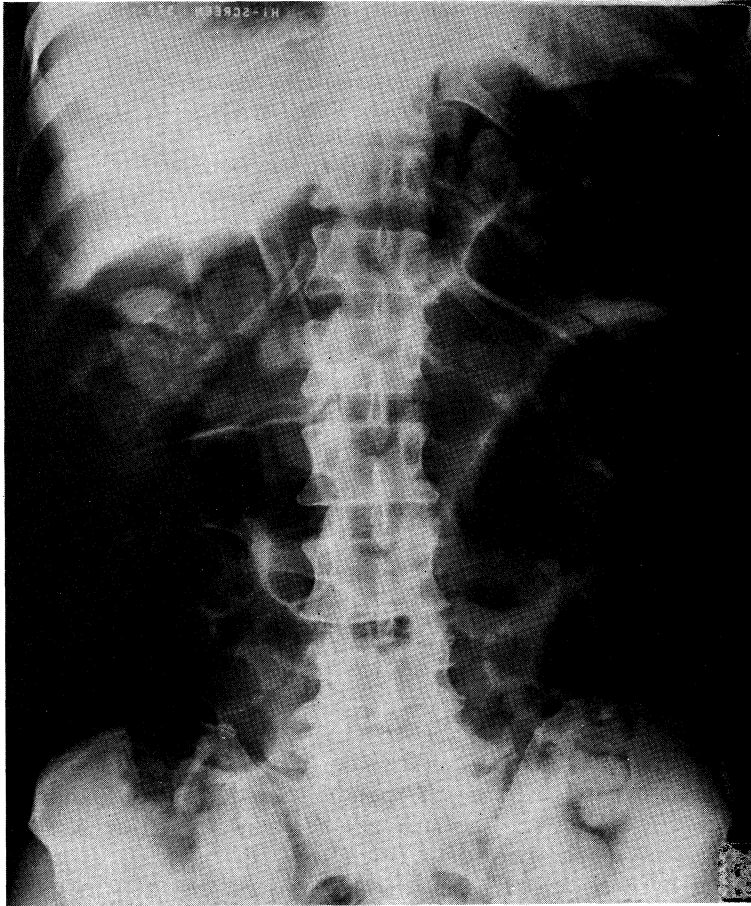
Plain antero-posterior X-ray films of the abdomen showing paralytic ileus.
